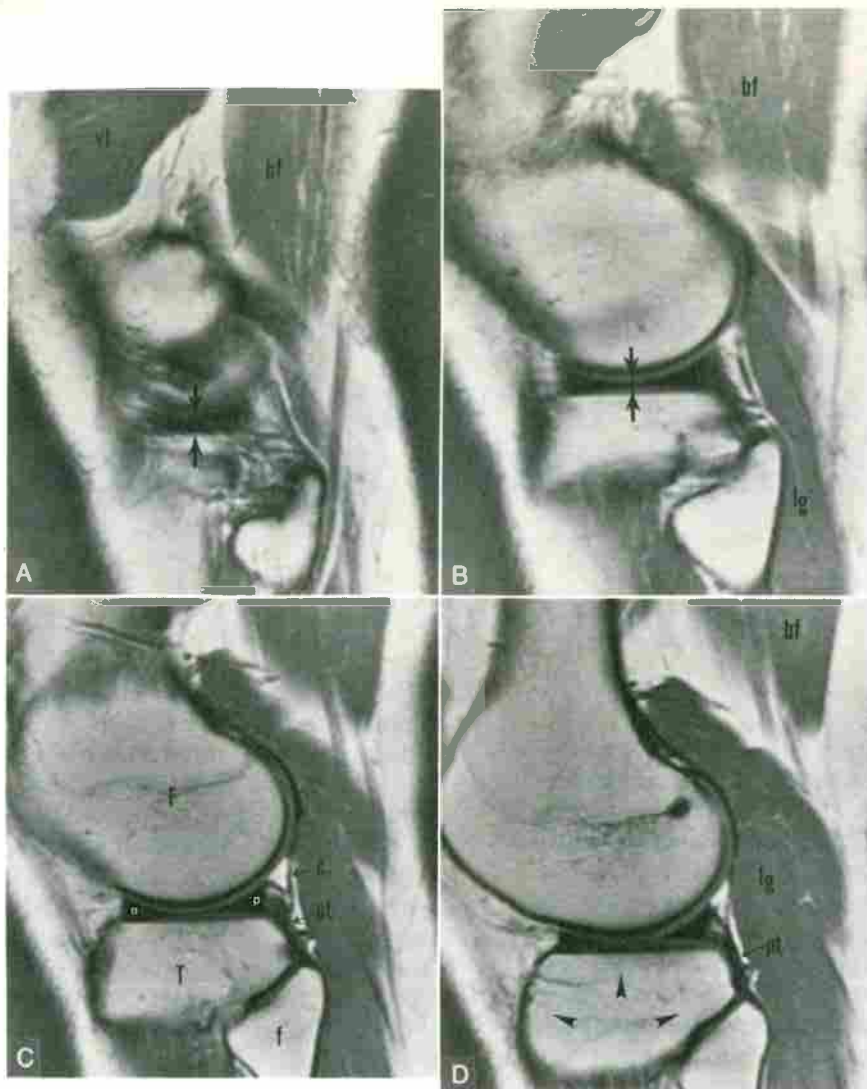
Normal knee. Four consecutive T1-weighted (TR/TE, 800/20) sagittal images through the lateral compartment of the knee joint. The two most lateral sections (A, B) show low-signal-intensity lateral meniscus (arrows) with the bow-tie configuration where the anterior and posterior horns are connected by the body of the meniscus. Note the rapid tapering of the body of the meniscus. C, An adjacent section toward the intercondylar notch shows the anterior (a) and posterior (p) horns of the lateral meniscus of nearly equal size. D, The next section toward the intercondylar notch demonstrates the flat articular surface of the lateral tibial plateau and the tuberosity projecting posteriorly and articulating with the fibular head (arrowheads). F, femur; T, tibia; f, fibula; c, joint capsule; bf, biceps femoris; vl, vastus lateralis; lg, lateral head of gastrocnemius muscle; pt, popliteus tendon.
